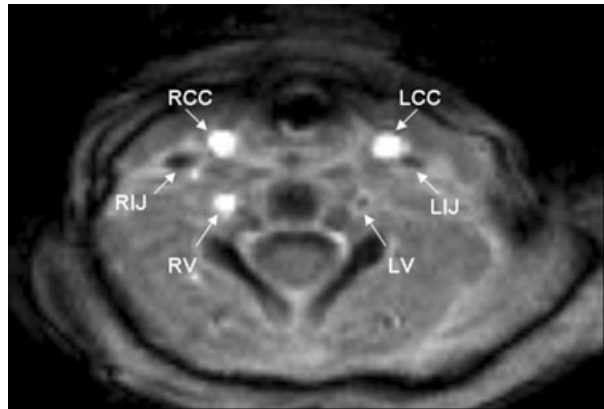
Magnetic resonance images using time of flight sequence at the level of the neck demonstrates directionality of blood flow in the neck vessels with bright areas (RCC, RV, LCC) within the arteries representing blood flow toward the head, and dark areas (RIJ, LIJ) within the veins representing blood flow toward the chest. The flow in the left vertebral artery is in the same direction as the veins representing retrograde flow within this artery. LCC, left common carotid artery; LIJ, left internal jugular vein; LV, left vertebral artery; RCC, right common carotid artery; RIJ, right internal jugular vein; RV, right vertebral artery.
